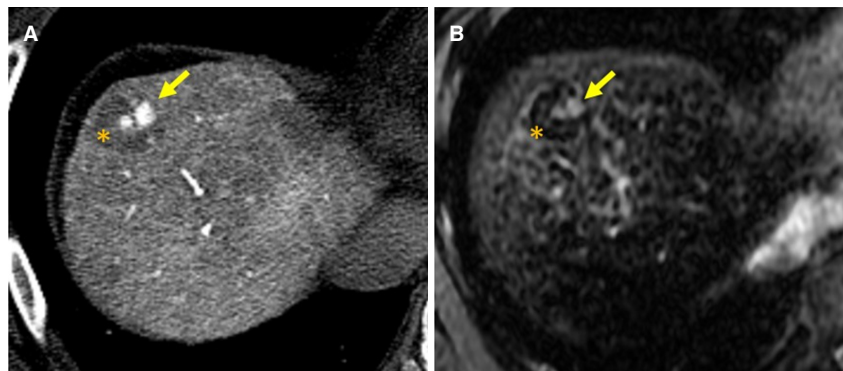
Example of nodule in nodule appearance lesion in alcoholic cirrhosis. A: CT during hepatic arteriography image of nodule in nodule lesion. Some hypervascular foci (arrow) are observed within hypovascular nodule (*); B: SPIO enhanced T2-MR image of nodule in nodule lesion. Small hyperintense spots, which do not uptake SPIO (arrow), are observed within the nodule which shows hypointensity because of uptake of SPIO (*). These findings represent the visualization of multistep hepatocarcinogenesis within the nodule. SPIO: superparamagnetic iron oxide
